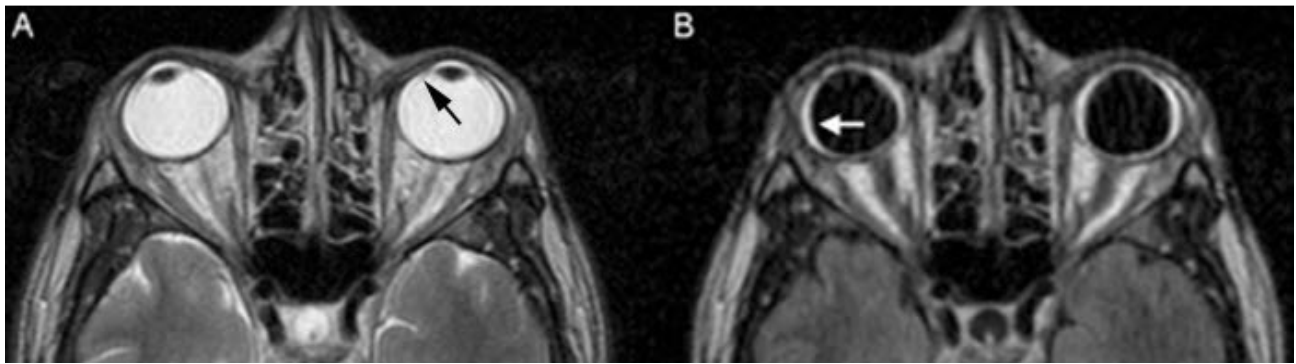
23 year old male with Kikuchi-Fujimoto disease. Axial T2 (2950/89) (A) and FLAIR (10002/126) (B) images demonstrate crescentic high signal along the periphery of the ocular globes bilaterally (arrows), reaching the level of the ciliary body, consistent with suprachoroidal fluid collections.
